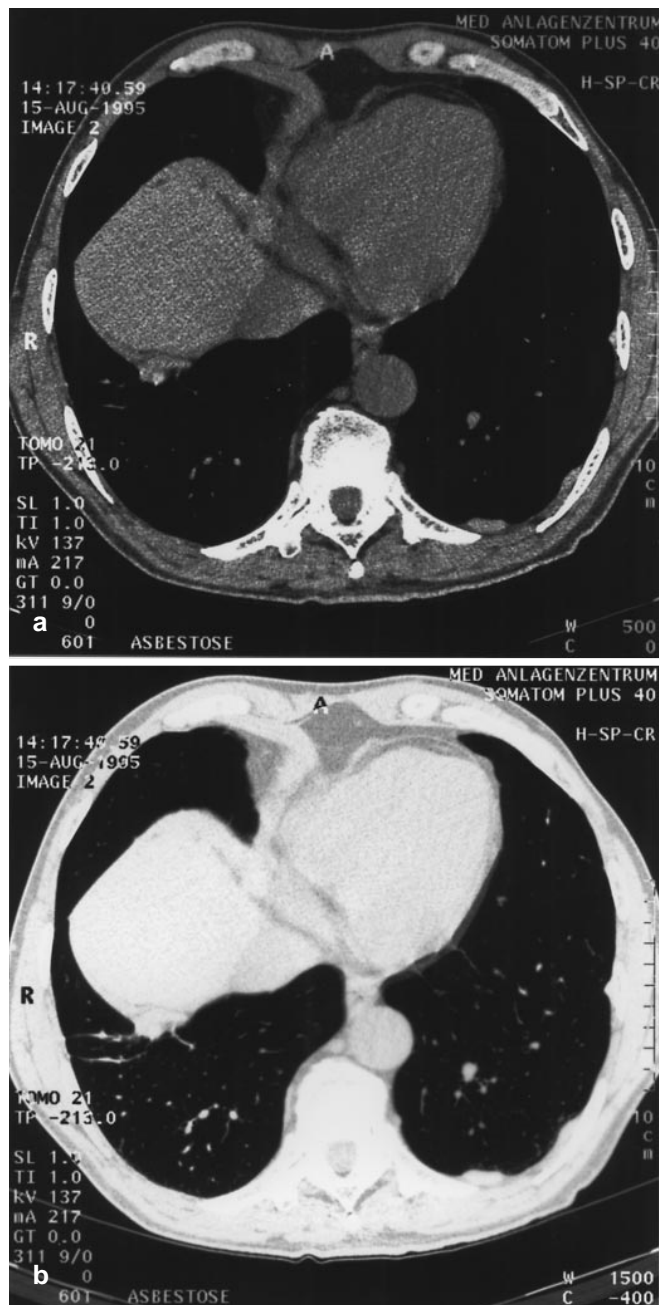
Representative HRCT scans of the insulator: several pleural plaques, left chest wall, and calcified plaque, right diaphragm, with parenchymal bands
